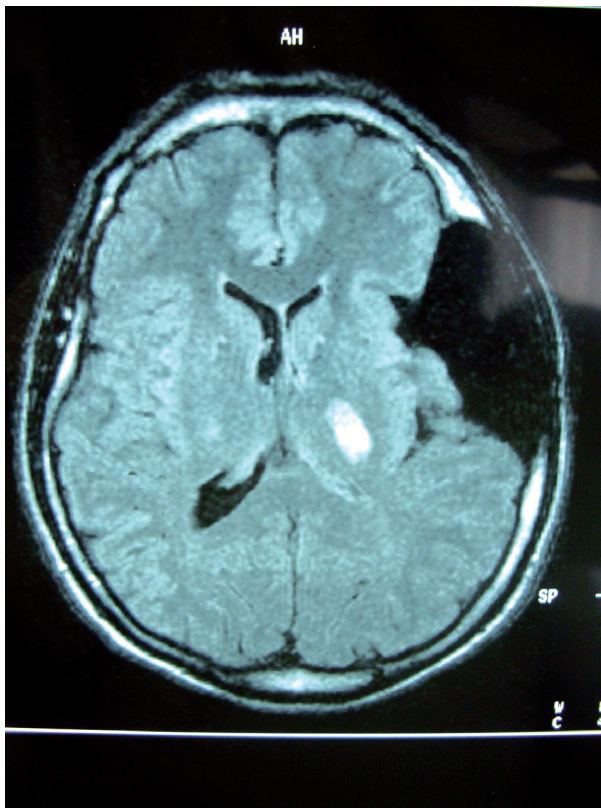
MRI on the arrival.
